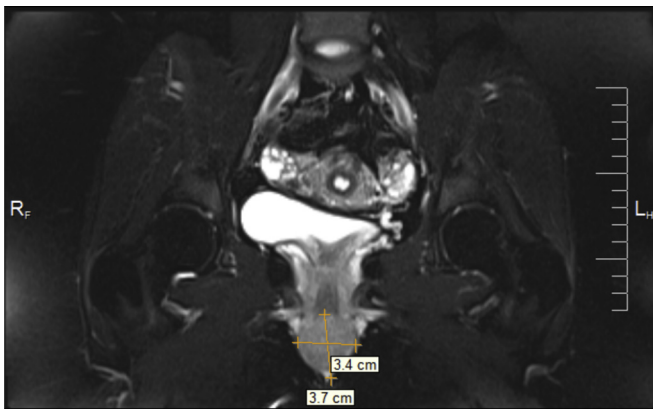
MRI showing size and location of paraurethral leiomyoma.
